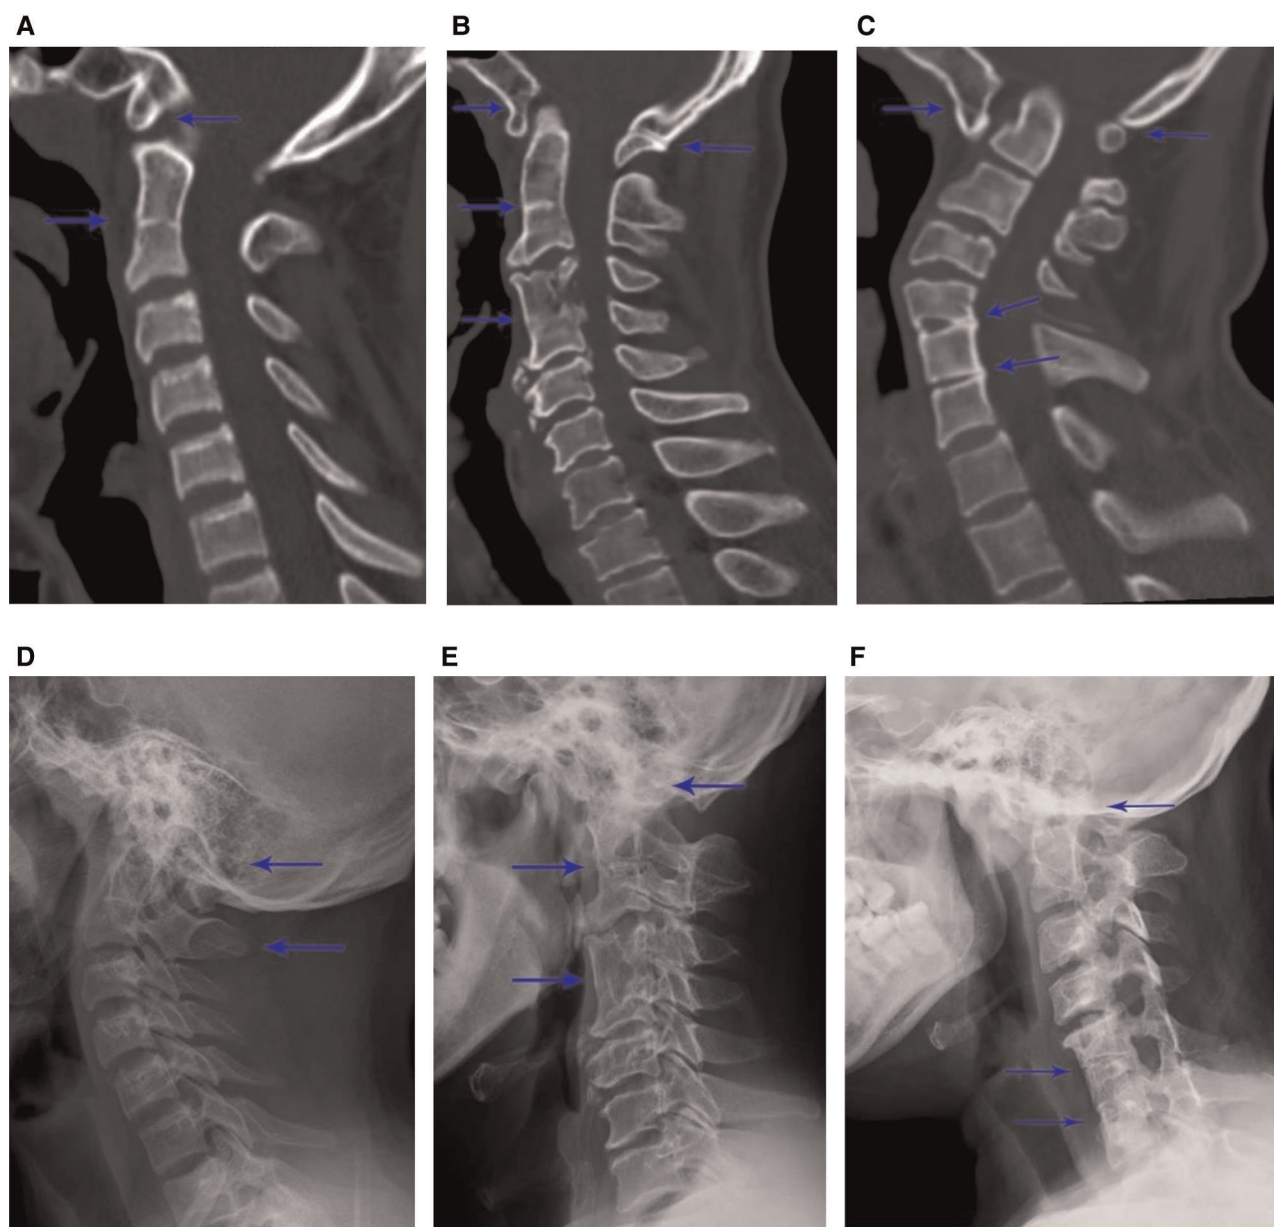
Patients with Klippel–Feil syndrome (KFS) and occipital fusion. Examples of different types of KFS patients with occipital fusion: type I – (A) computed tomography (CT) scan and (D) radiograph showing C2–3 single fusion with occipital fusion; type II – (B) CT scan and (E) radiograph showing noncontiguous levels of fusion (C2–3 and C4–5) with occipital fusion; type III – (C) CT scan and (F) radiograph showing three levels of contiguous fusion at C5–7 with occipital fusion. The site of fusions is indicated by arrows.
